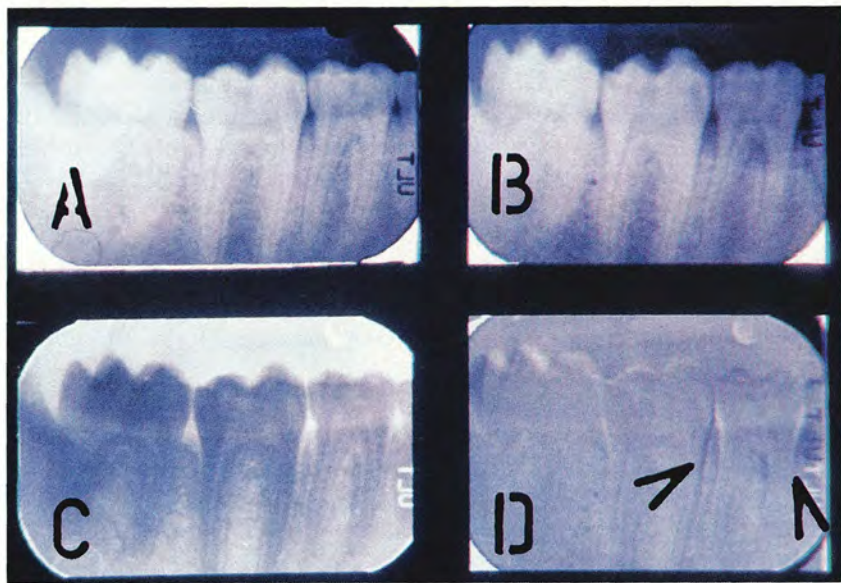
Subtraction radiography: (a) initial radiograph, (b) follow-up radiograph with suspected change, a periodontal defect in this case, (c) reversal of initial radiography, usually called a mask, and (d) the subtraction radiograph, which is the result of combining "b" and "c."
